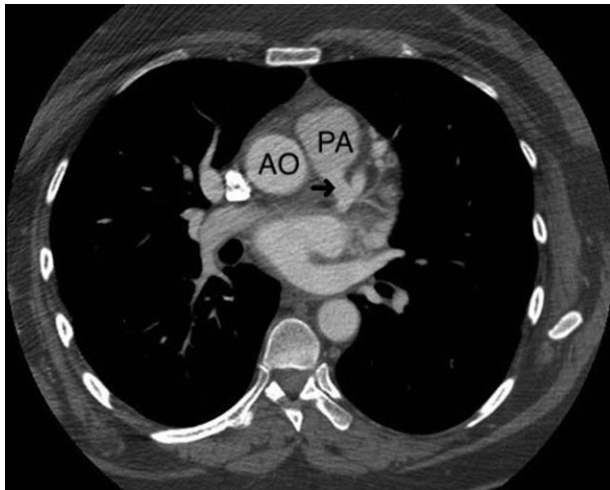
CT angiogram showed the anomalous origin of the LMCA arising from the main pulmonary trunk (arrow). PA, pulmonary artery; AO, aorta; RCA, right coronary artery; RSV, right sinus of Valsalva; LMCA, left main coronary artery.
